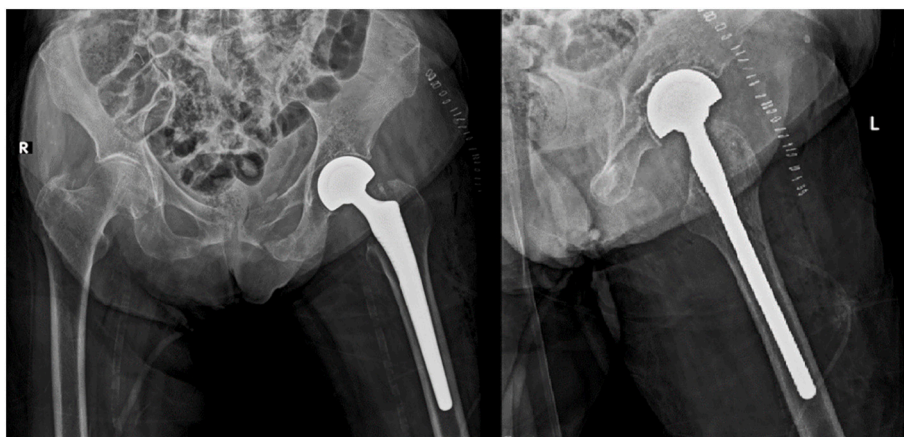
Post-operative antero-posterior (left) and lateral (right) views plain radiographs of the pelvis and left hip showing a left hip hemi-arthroplasty with associated left superior and inferior pubic rami fractures.
